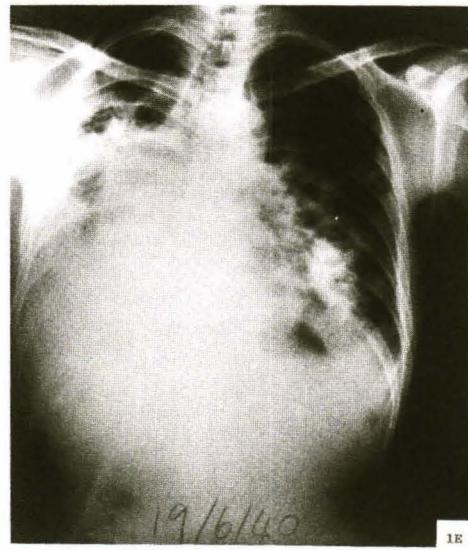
The final chest radiograph after the patient had developed severe *Klebsiella pneumoniae*.
